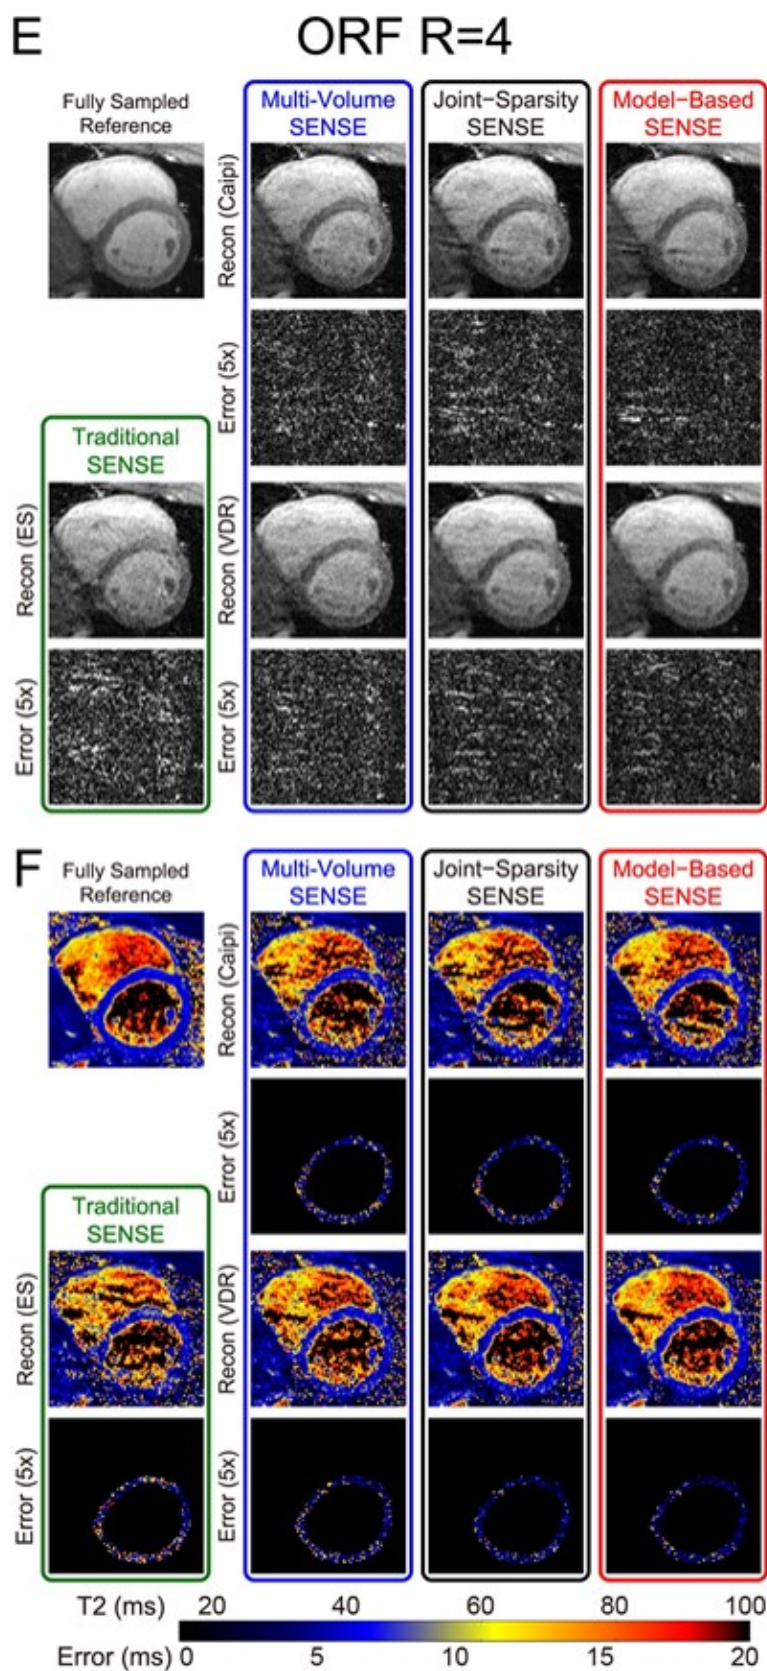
T2-weighted images and T2 maps of a normal human with ORF=2-4 and all reconstruction approaches. Comparison of images with T2-Prep TE of 45 ms (A,C and E) and T2 maps (B, D and F) obtained from normal human subject (different from the case in Fig. 2.2) using ORF= 2(A,B), 3(C,D) and 4(E,F) for all sampling and reconstruction approaches. Error maps are multiplied by 5 for increased visibility, and T2 map error maps are masked with the segmented left ventricular ROI. As ORF increases (left to right), artifacts become apparent for all methods, most severely for traditional SENSE and least for VDR sampling.
